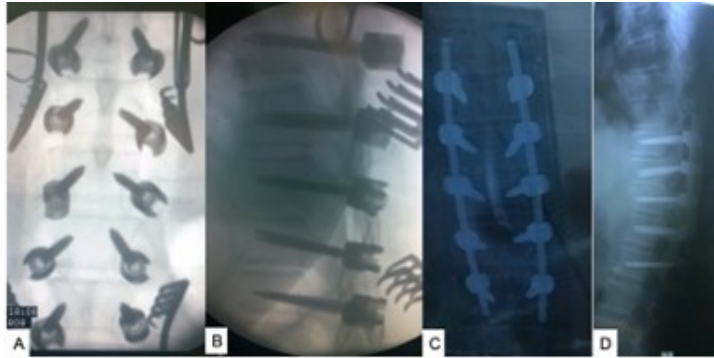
(A,B) Intraoperative X-ray of fracture reduction, stabilization (with pedicular screws and rods), and fusion of D11 fracture and dislocation in patient in Figure 13. (C,D) Postoperative X-ray of patient in Figure 13. Source: Figure by authors.
